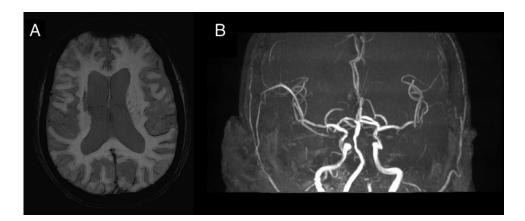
(A) Repeat MRI on day 5 shows near complete resolution of the prominent hypointense vessel sign, on the susceptibility-weighted imaging (SWI) sequence. (B) MRA image showing revascularization of the previously occluded left MCA.
